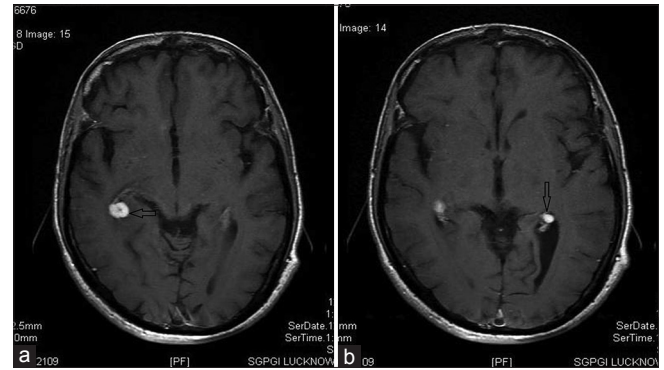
(a) Lesion shows intense contrast enhancement on postcontrast T1-weighted image. (b) Small, nodular enhancing lesion seen in left atrium (black arrow)
